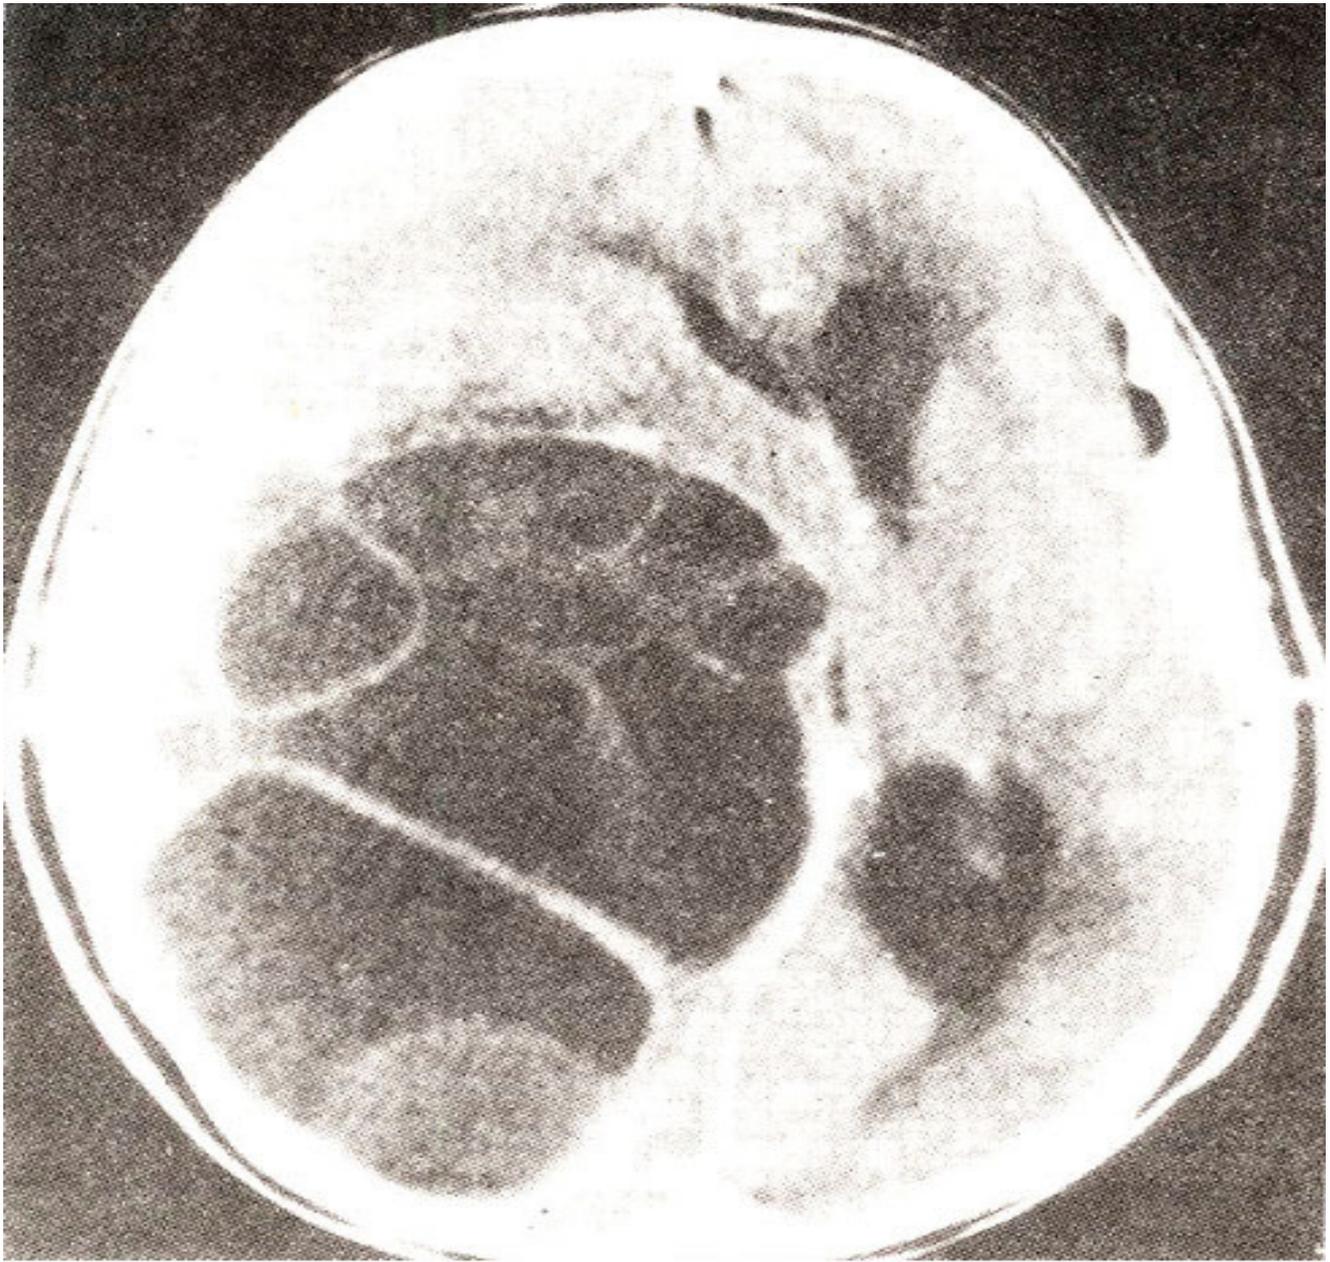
Pre-operative CT head with contrast showing multiple confluent cysts with well demarcated margins causing mass effect and midline shift
